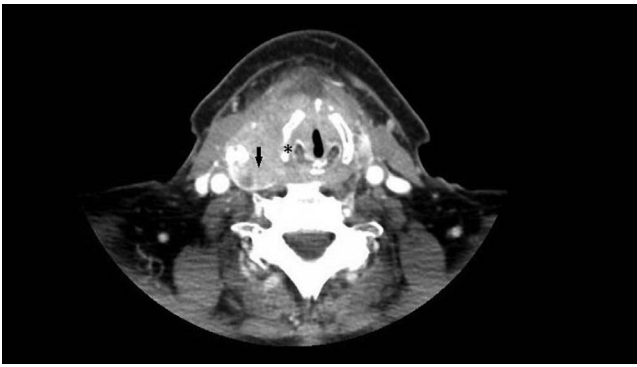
Axial computed tomography scan with contrast demonstrates a heterogeneous thyroid mass (arrow) with areas of necrosis as well as calcification and invasion of the paraglottic space (asterisk).
